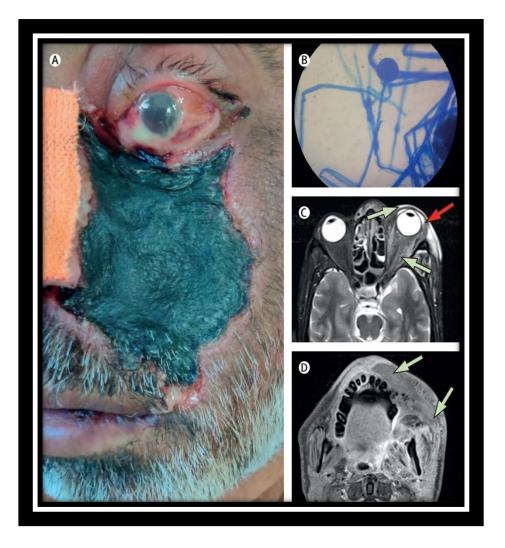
Mucormycosis CT scan images
